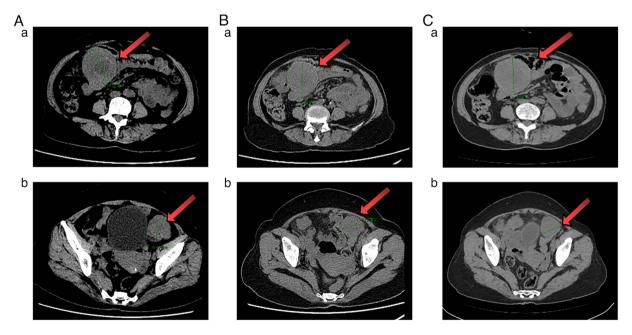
CT examination after first-line therapy. (A) 11.2 months, (B) 14.2 months and (C) 14.9 months after the first cycle of first-line therapy. (Aa-Ca) Cross-section in peritoneal cavity (green boundaries); (Ab-Cb) cross-section in pelvic cavity. Maximum cross-section diameter of the mass (green boundaries) in the peritoneal cavity  $(6.9 \rightarrow 6.2x7.1 \rightarrow 7.0x7.1$  cm). Maximum cross-section diameter of the mass (green boundaries) in pelvic cavity  $(5.0 \rightarrow 4.5 \rightarrow 4.5$  cm). The largest masses are also highlighted (red arrows).
